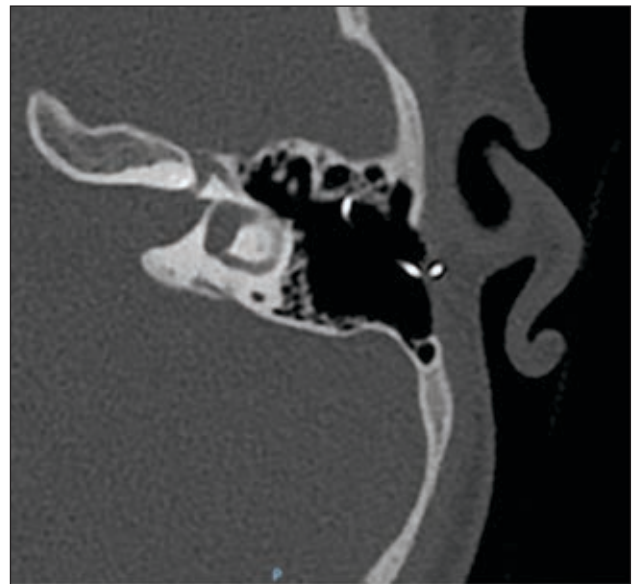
CT image before the first cochlear implantation (2019)
